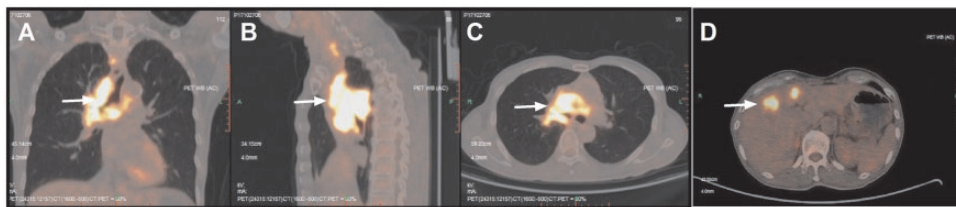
Coronal (a), sagittal (b) and axial (c) positron emission tomography/computed tomography images of a 64-year-old man who presented with a painless mass below the right ear and complained of peripheral facial paralysis for a month showing a hypermetabolic lesion in the right upper and middle lobes and intermediate bronchus, with features of central lung cancer (white arrow). Localized thickening and hypermetabolism under the right lobe of liver (d, white arrow) suggests possible liver metastasis.
